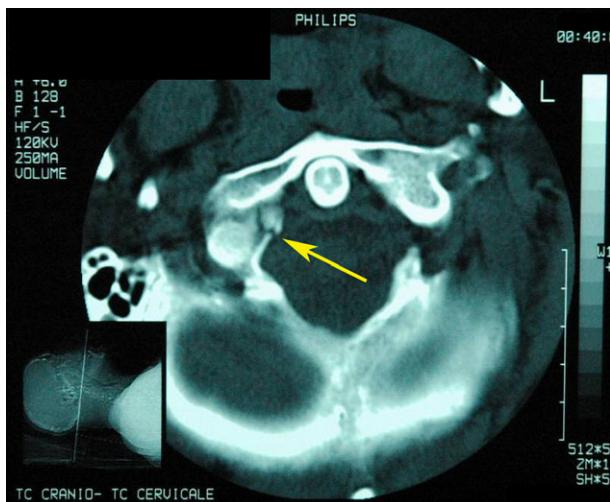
CT imaging showing the right occipital condyle fracture (arrow).
